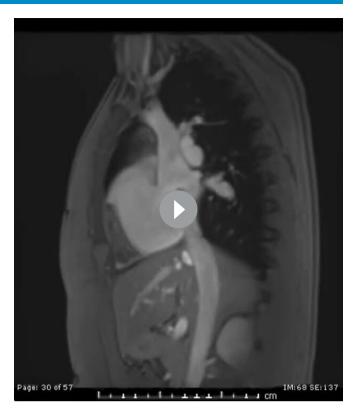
CMR with steady-state free precession cine (A) and phasecontrast imaging (B) in bicaval view showed superior sinus venosus atrial septal defect (red arrow) and anomalous right upper PV return to SVC (asterisk). CMR with volume rendering technique in posterior view with the removal of descending thoracic aorta (C) showed 4 PVs draining into LA (arrowheads) and an anomalous right upper PV return to SVC (asterisk). CMR with volume rendering technique in anterior view (D) showed an anomalous branch of right middle PV return to SVC (white arrow). CT pulmonary angiography in axial view (E) showed an anomalous branch of right middle PV return to SVC (white arrow). Ao, aorta; CMR, cardiac MR; IVC, inferior vena cava; LA, left atrium; MPA, main pulmonary artery; RA, right atrium; PV, pulmonary vein; SVC, superior vena cava.
